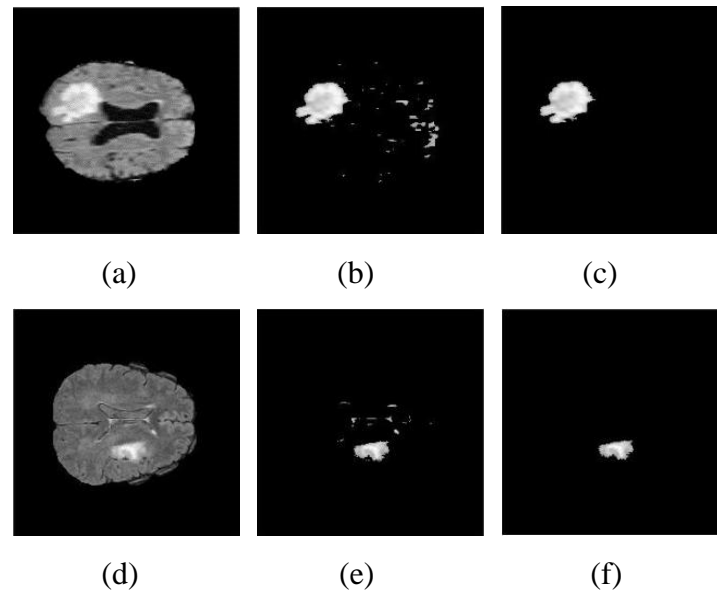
11 (a) Original HGG MR image, (b) Extracted tumor by existing GC, (c) Extracted tumor by proposed GBKS GC method, (d) Original LGG MR image, (e) Extracted tumor by existing GC, (f) Extracted tumor by proposed GBKS GC method
